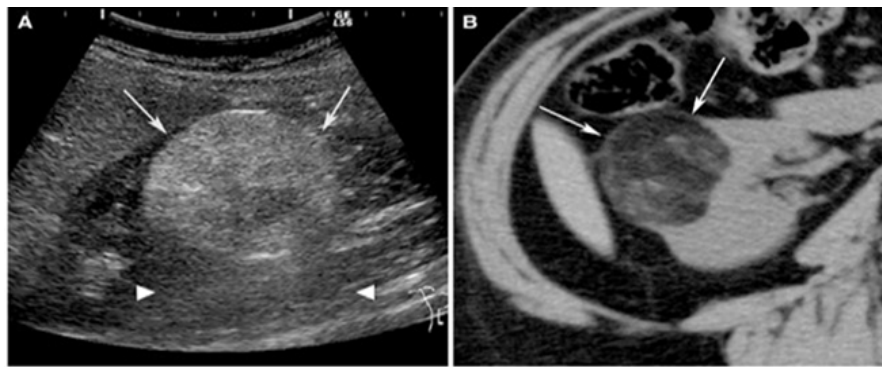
(A and B) Ultrasound and non-enhanced CT scan show a hyperechoic to parenchyma and fat density well-defined mass with acoustic shadow (angiolipoma).
